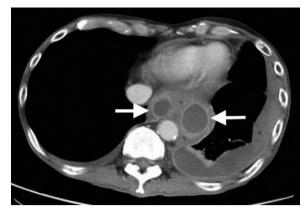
Chest CT scan revealing mediastinum abscess formation (arrows).
